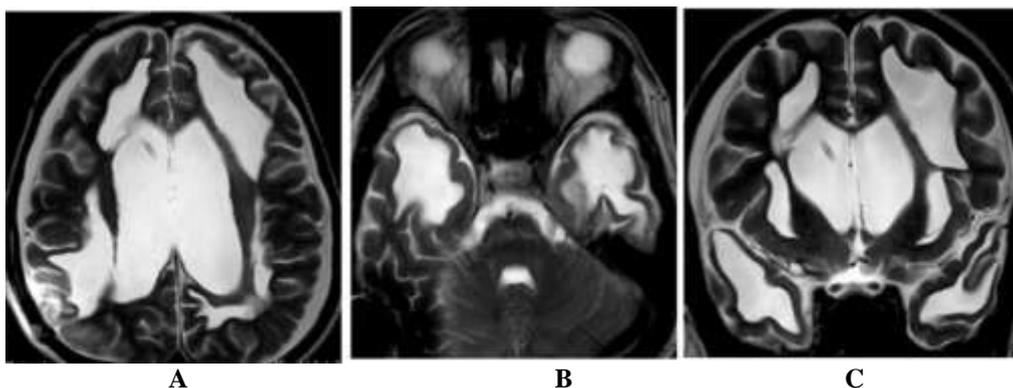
(A-C) 15 year old male, known case of congenital CMV infection with past history of tuberculosis and shunt tube in situ for ventriculomegaly. MRI showing diffuse loss of white matter with cystic periventricular changes, also in the anterior temporal lobes alongwith cerebral atrophy and ventriculomegaly.
